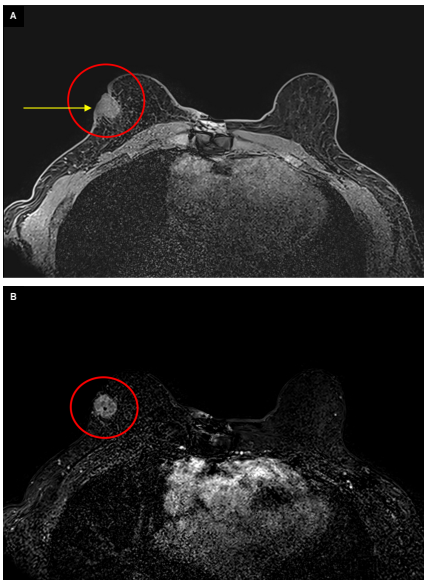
Contrast-enhanced breast MRI precontrast (A) and initial postcontrast subtraction (B) completed 1 month after initial diagnostic mammogram and US demonstrated an enhancing mass with overlying skin thickening (yellow arrow). No additional suspicious enhancing findings were identified.
